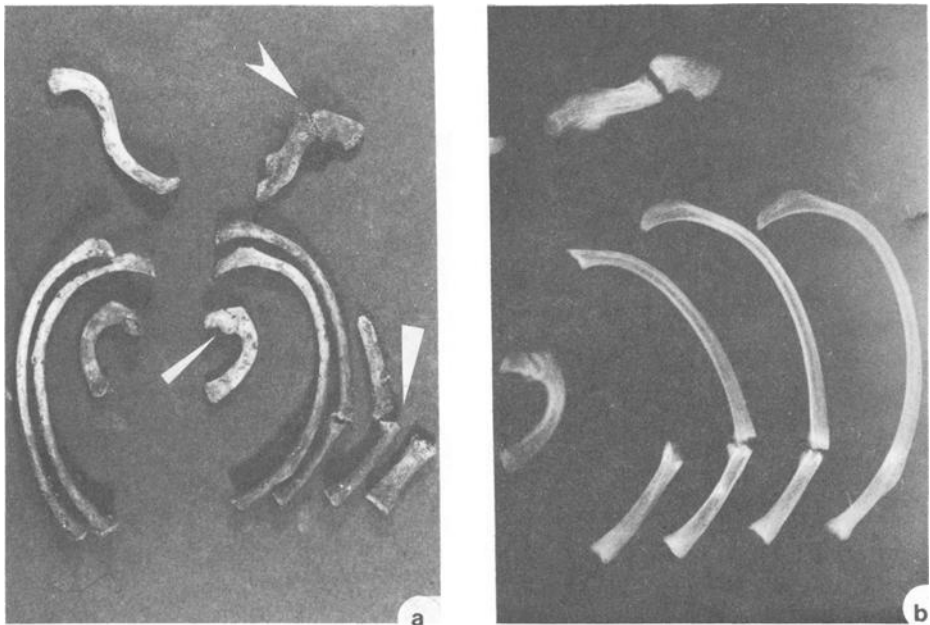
(a) Ribs and clavicle of Body B. (b) Radiograph showing healing fractures.
